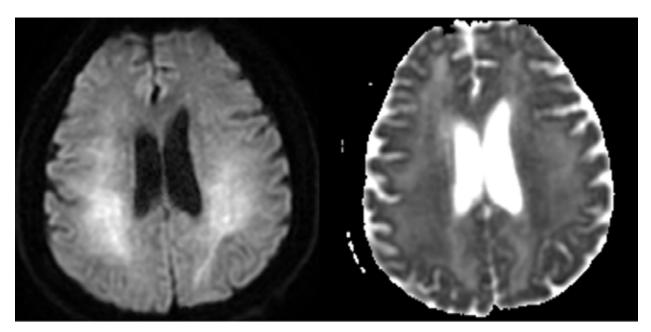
Diffusion-weighted imaging (left) and the apparent diffusion coefficient (right) of brain magnetic resonance imaging.
